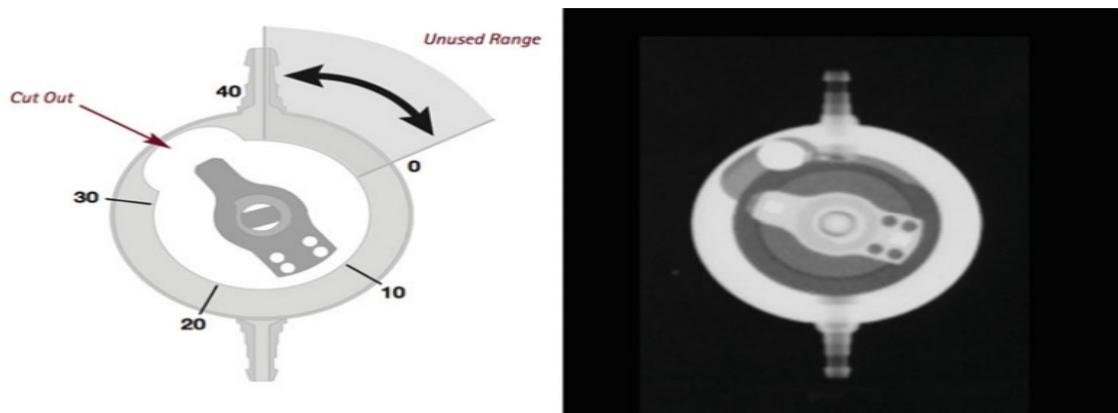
proSA x-ray verification
